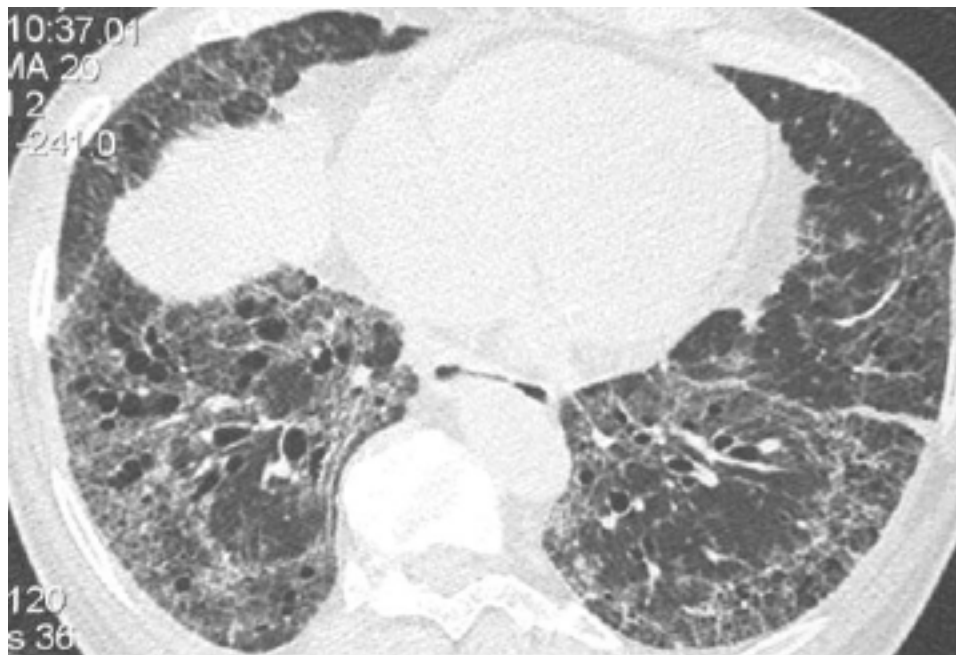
Followup HRCT scan 7 years later at the same level in the same patient as in Figure 3. Note areas of microcystic honeycombing, mostly peripherally located, as well as ground-glass attenuation and traction bronchiectasis, more extensive in the right lower lobe, both indicative of lung fibrosis also suggested by lung retraction. Note abnormal dilatation of the esophagus.
